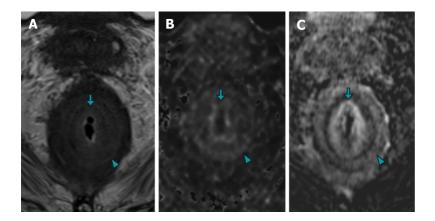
Magnetic resonance imaging images of case 1 demonstrating concentric "target-like" involvement of the rectal parietal wall due to secondary linitis plastica. A: The axial images obtained from T2 turbo spin echo sequence; B: Diffusion-weighted imaging (DWI); C: T1 gradient recalled echo volumetric interpolated breath-hold examination with contrast-enhanced subtraction technique revealed a stratified parietal thickening of the rectal wall. This thickening displayed concentric areas of intermediate signal intensity on T2-weighted images, restricted diffusion on DWI, and enhancement on contrast-enhanced images, affecting both the submucosal (arrow) and muscular (arrowhead) layers.
